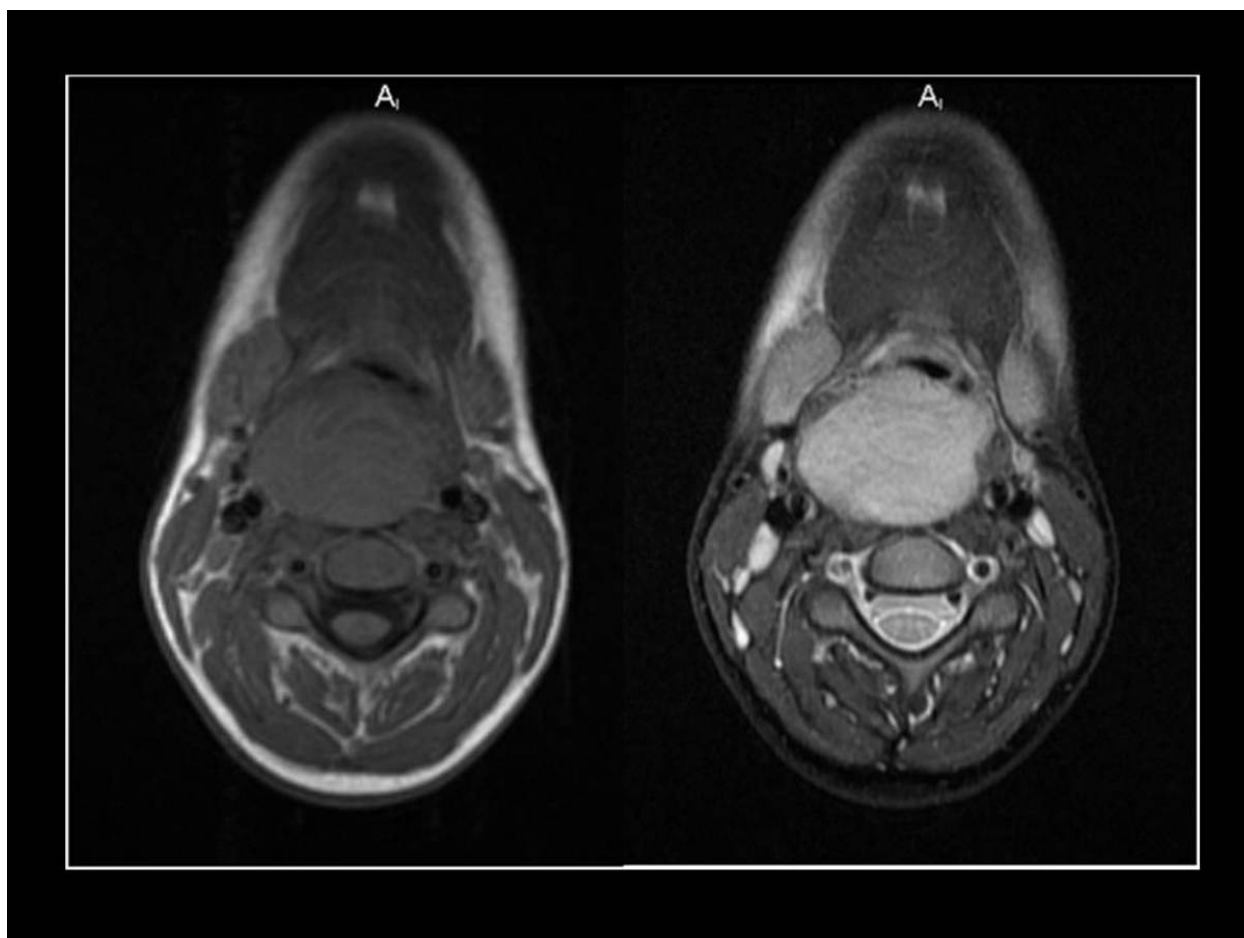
Nasopharyngeal hemangioma. Male, 74 years old, suspected of having a nasopharyngeal carcinoma. Axial nasopharyngeal FSE MR images show a homogeneous mass, hypointense on T1-weighted (left) and moderately hyperintense on T2-weighted (right) occupying the posterior and left walls of the nasopharynx. The mass blunt the Rosenmüller fossa and appeared to invade the longus capitis and longus colli muscles.
